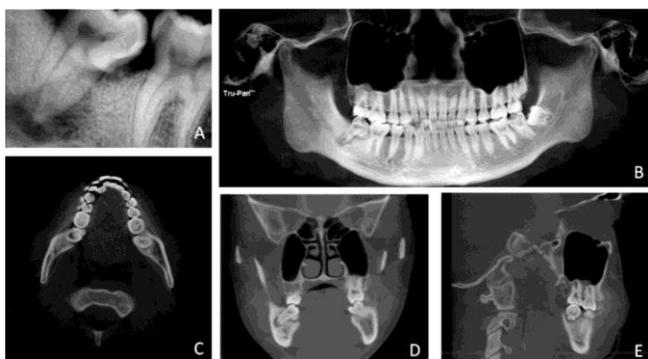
(A): Periapical and (B): OPG radiograph shows small radiopacity around #47, axial. (C): Coronal (D): and sagittal (E): view of CBCT show two crowns of #47 with single root canal system.
